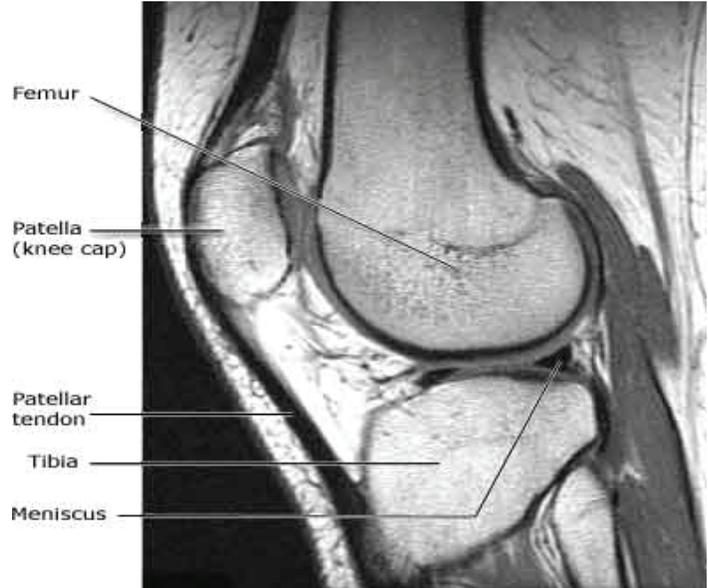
MRI image - lateral view of knee.
